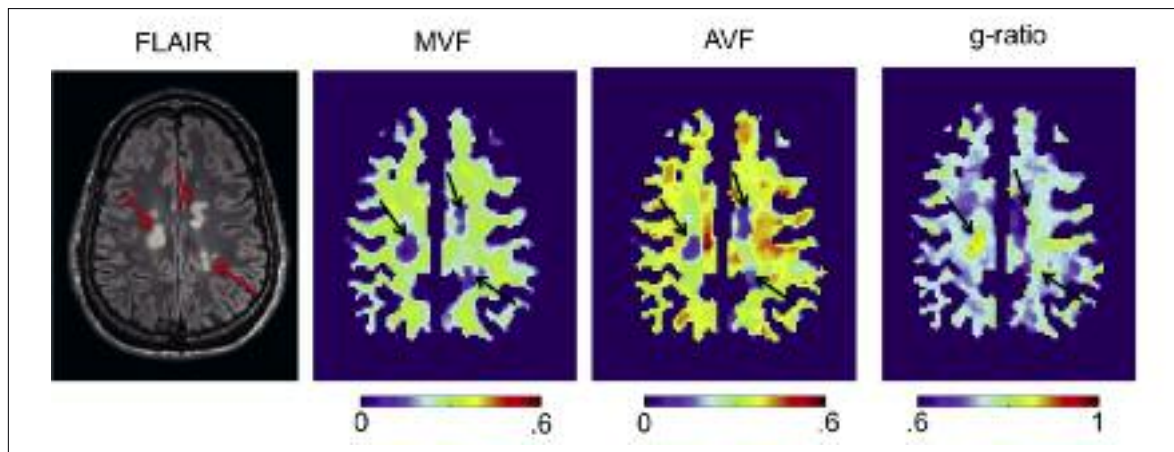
Example of multi-parametric quantitative MRI maps of a multiple sclerosis patient.
